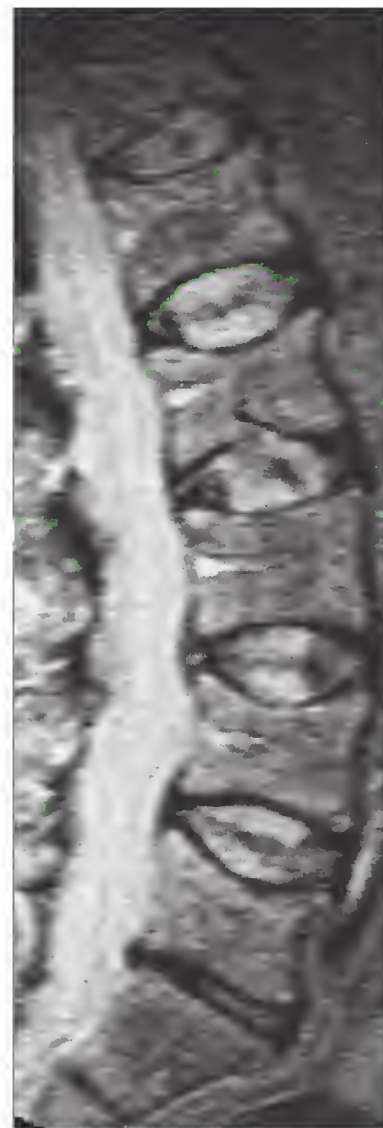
Lumbar spine magnetic resonance imaging study of a patient with multiple myeloma and abnormal bone marrow signal throughout the vertebral bodies associated with remodeling and pathologic fractures.
